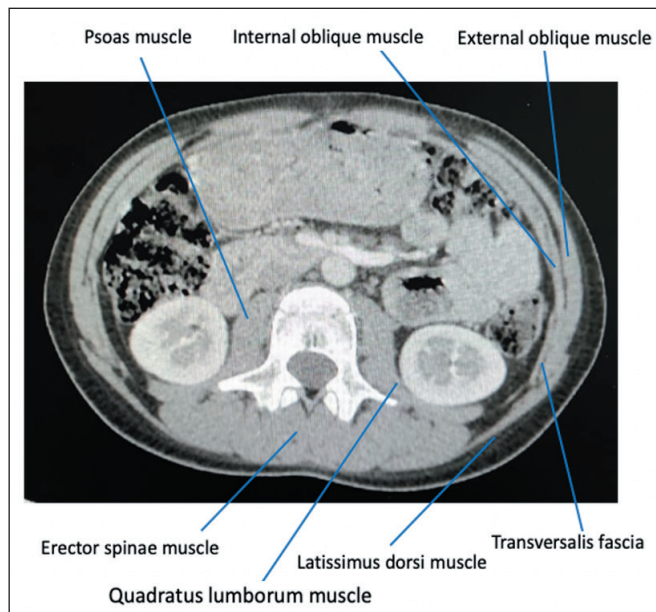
Axial abdominal CT image demonstrating anatomical structures adjacent to the superior lumbar (Grynfeltt-Lesshaft) triangle, including the quadratus lumborum, erector spinae, internal oblique, external oblique, latissimus dorsi muscles and transversalis fascia.
